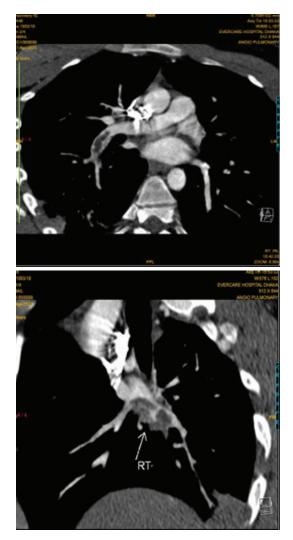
CT pulmonary angiogram coronal & axial section showing thrombus in right interlobar artery extending inferiorly into the lower lobe artery, lateral basal and posterior basal segmental / subsegmental arteries.
